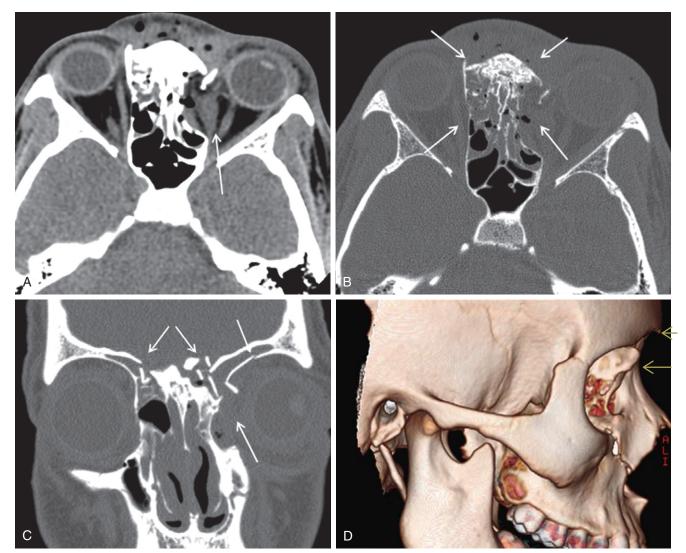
Trauma to the face: Naso-orbital ethmoidal complex fractures. A, Axial CT image on soft tissue window delineates extent of soft tissue injury to the orbit. *Arrow* points to a hematoma and displacement of the medial rectus muscle. B, Axial image on the bone window setting delineates complex, comminuted, and displaced fractures of the medial orbital walls/lamina papyracea (*posterior arrows*) and cribriform plate (*anterior arrows*). C, Coronal reconstruction delineates the complex comminuted fractures, which also include the frontal sinuses and fovea ethmoidalis (*diverging arrows*) and left orbital roof (*upper arrow*), and redemonstrates the extensive fracture of the medial orbital wall/lamina papyracea (*lower arrow*). D, Lateral view of the 3D reconstruction demonstrates the marked posterior displacement of the nasoethmoidal complex (*long arrow*) in relation to the frontal sinus/frontal bone (*short arrow*).
